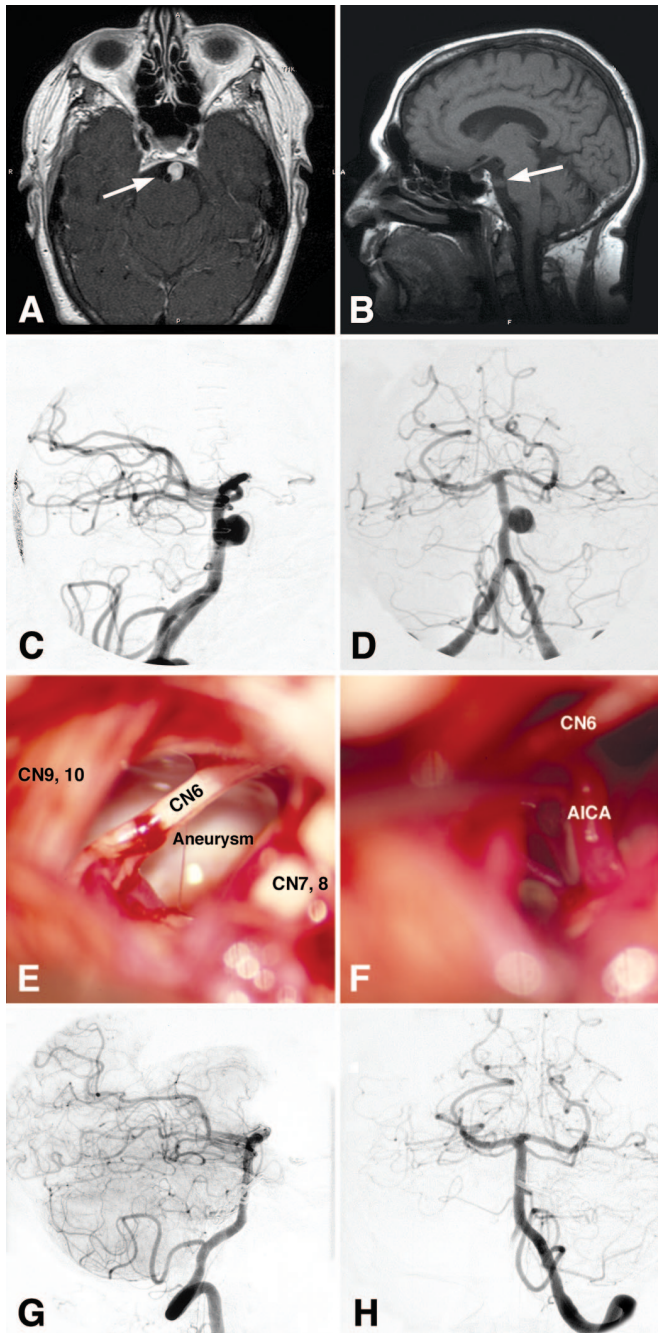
Preoperative T1-weighted MRI scans in the axial with contrast (A) and sagittal without contrast (B) planes demonstrate a 10 mm sacular aneurysm (arrows) along the basilar artery anterior to the pons. Digital subtraction angiography with injection of contrast in the right vertebral artery shows an aneurysm at the origin of the left AICA (C, lateral view; D, anterior-posterior view). E, intraoperative photographs show the important cranial nerves involved around the aneurysm as well as the aneurysm in view through the exposed window. F, intraoperative photographs show that the involvement of the AICA, as well as the course of the 6th cranial nerve (CN6). G and H, postoperative angiography in the lateral and anterior-posterior views demonstrating successful clipping of the aneurysm, with preservation of blood flow in anterior inferior cerebellar artery.
